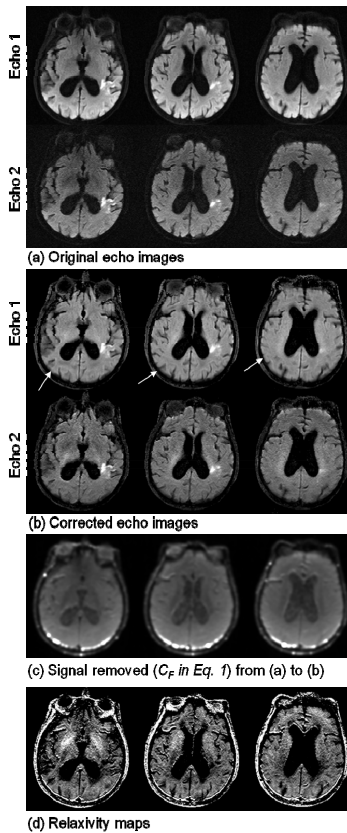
Data collected on a 91 yr old male stroke patient (a) Original dual echo images, and (b) the dual echo images with contribution from coil sensitivity, proton density, initial magnetization and B1 removed (as in (c)). The corrected images rule out any suspicion of posterior lesions (white arrows). Note the increased contrast of the stroke lesions on echo 2. (d) Relaxivity maps calculated from the average contribution of the T2-w and DWI dual-echo images.
